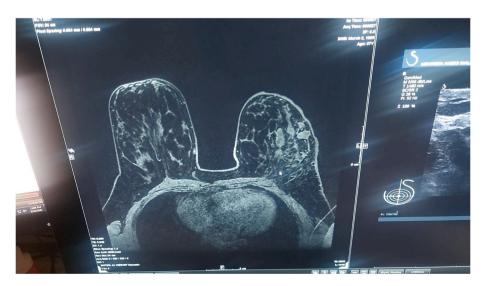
Showed magnetic resonance imaging of granulomatous mastitis.
